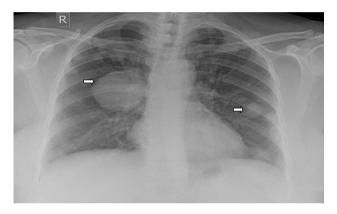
Chest X-ray of a patient with ACC-vulva recurrence showing multiple pulmonary metastases (marked by *arrows*)
